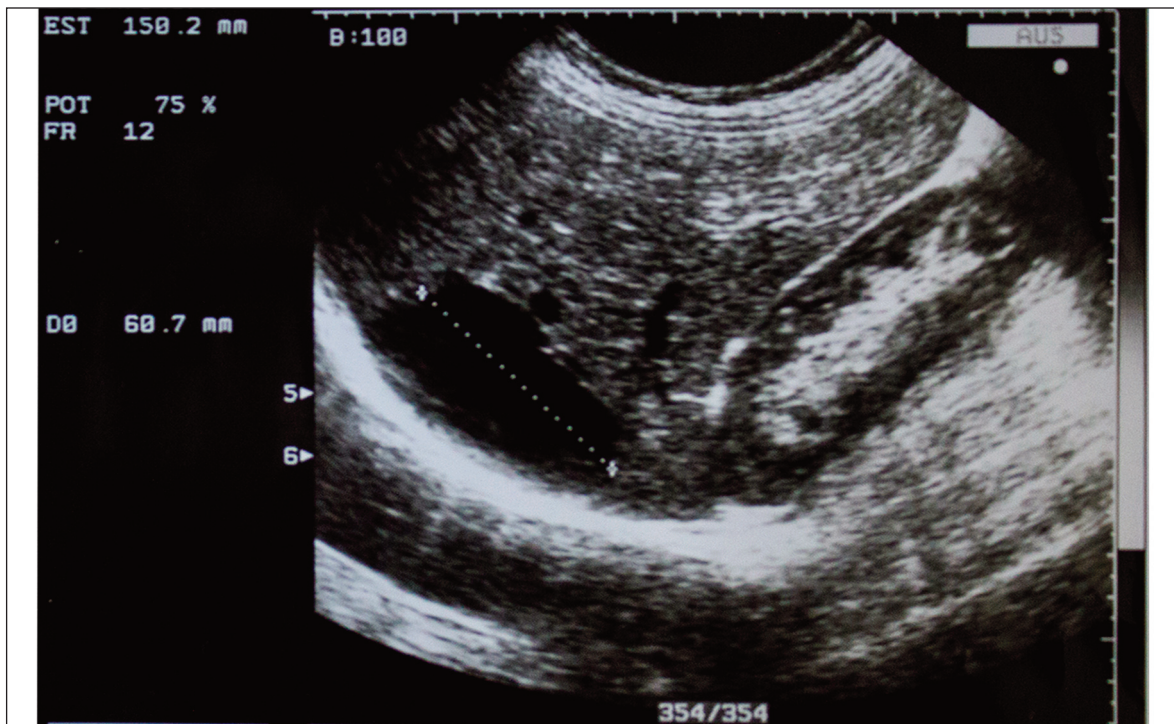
Ultrasonography image: other simple liver cysts.
